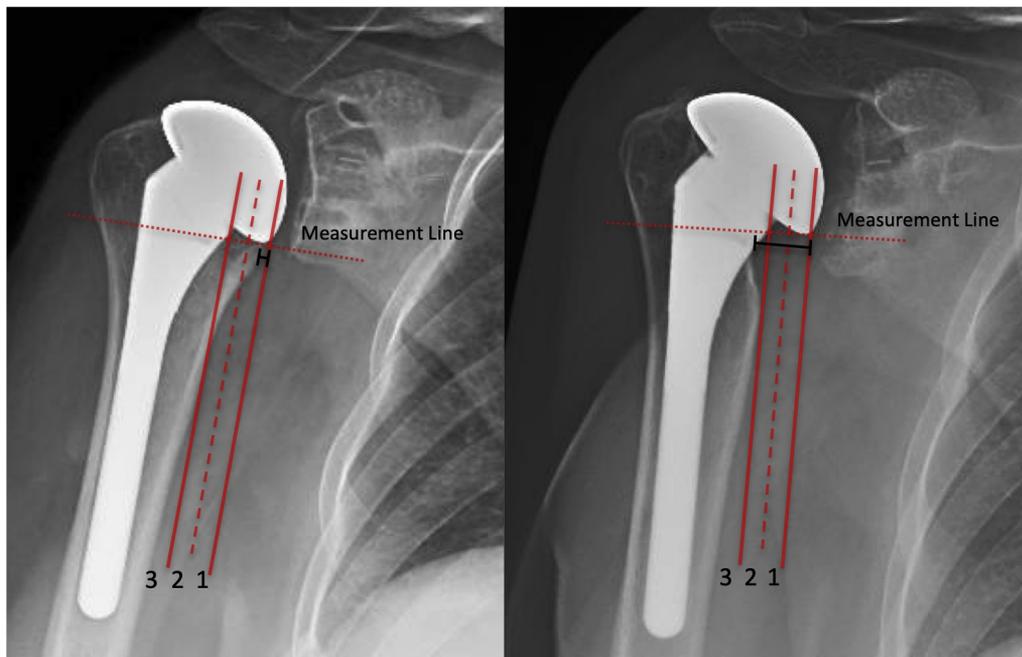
Calcar resorption grading system using anteroposterior radiographs. Calcar height is measured at the inferior level of the humeral head. As the calcar resorption progresses, the grade increases. Grade 1 denotes the zone between the *solid medial line* and the *dashed line*. Grade 2 denotes the zone between the *dashed line* and the *solid lateral line*. Grade 3 denotes the zone medial to the *solid medial line*. This patient shows significant progression from grade 1 at 3 months (*left*) to grade 3 at final follow-up (*right*).
